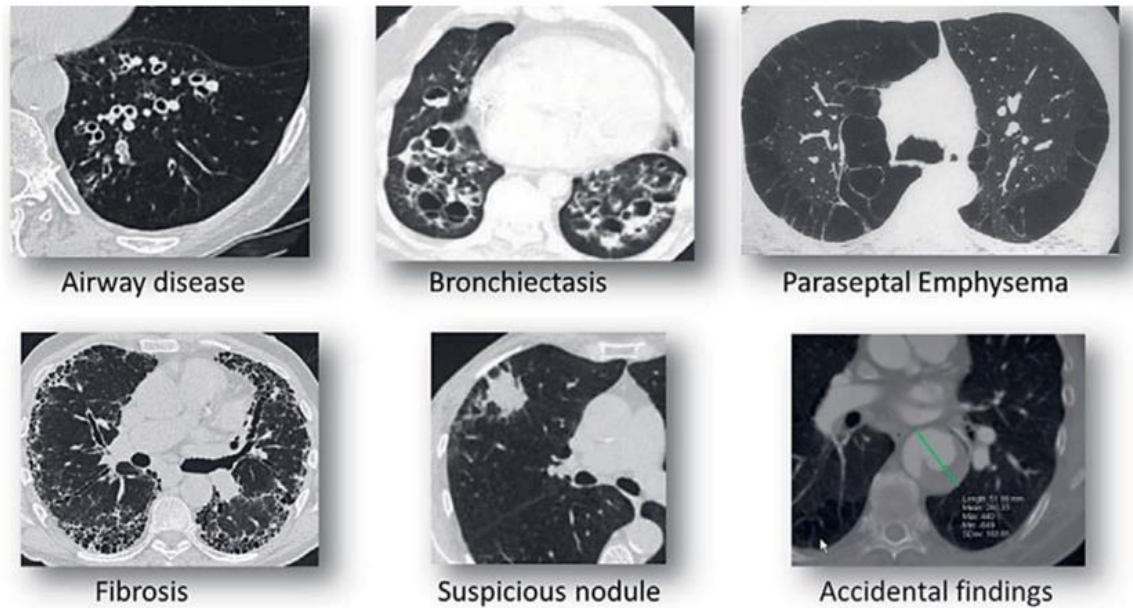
Chest CT scan images that are not recommended for BLVR.
